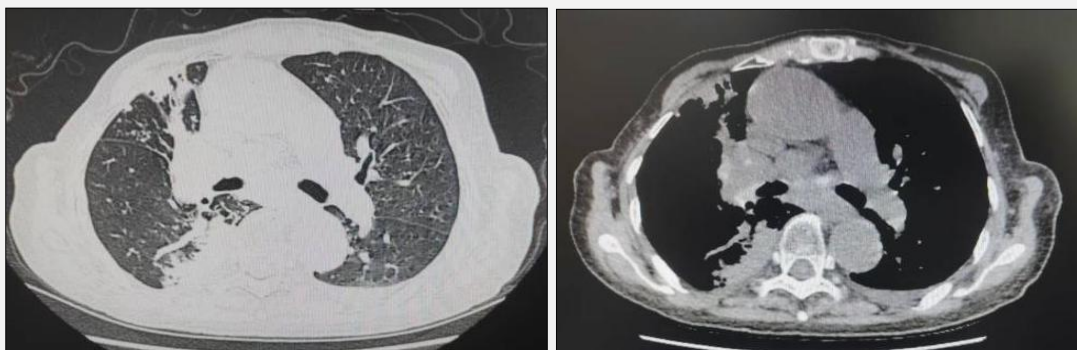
2025-02-06 Chest CT shows patchy infiltrative shadows in the right lower lobe of the patient's lungs, along with thickened lung markings throughout the lung fields.
